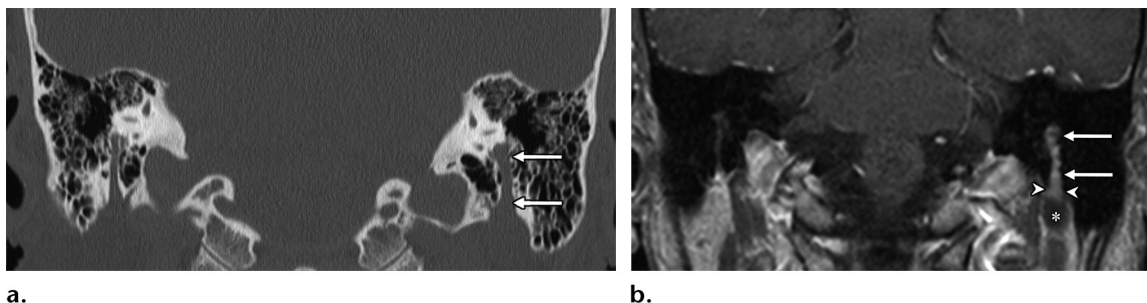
Clinically diagnosed mastoid segment CN VII schwannoma in a 62-year-old woman. (a) Coronal temporal bone CT image shows asymmetric enlargement of the left mastoid segment of CN VII (arrows). (b) Coronal contrast-enhanced T1-weighted MR image shows an enhancing schwannoma in the expanded left mastoid segment (arrows), with a nonenhancing cystic portion (*) bulging out of the stylomastoid foramen (arrowheads).
